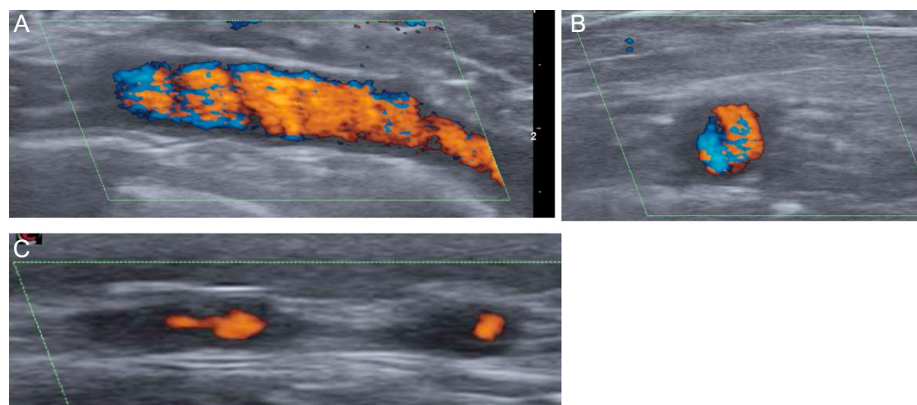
Ultrasound of the temporal artery of a patient with active ACG. Halo sign (arrowhead) on longitudinal (A) and trans(B) scan. Stenosis (line) of the temporal artery (C).
